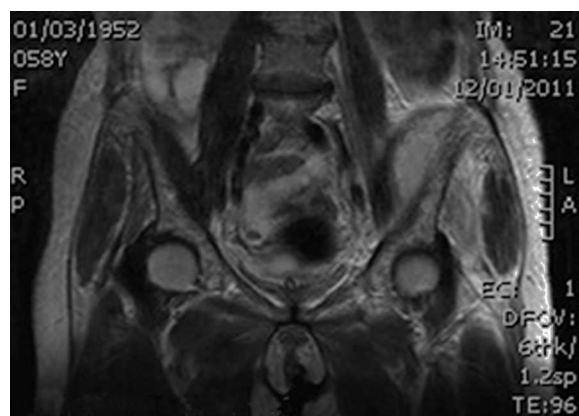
Magnetic resonance imaging of the abscess (T2-weighted, coronal section).
